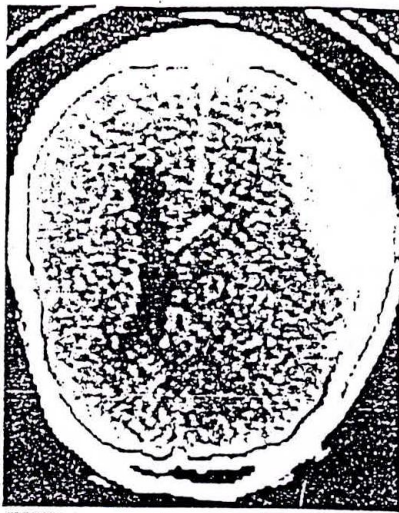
CT scan. Acute extradural haematoma.
